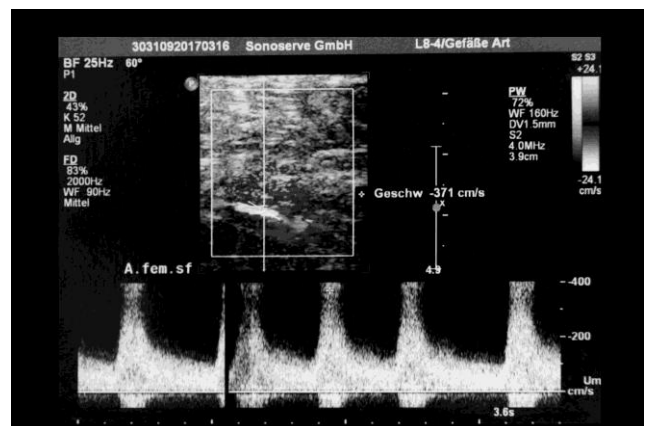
Duplex sonography of left A. femoralis superficialis
